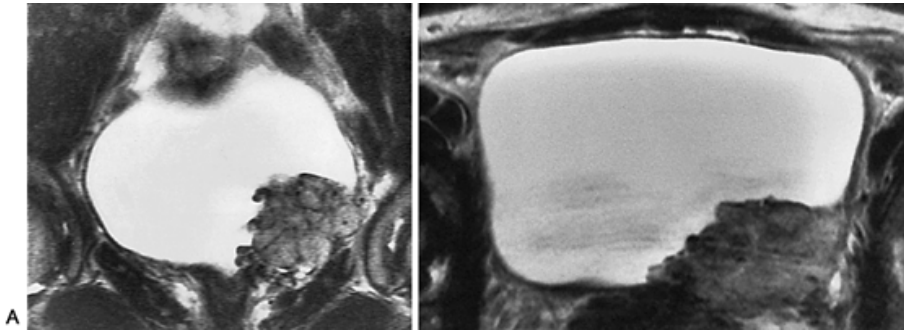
20. Transmural invasion of bladder tumor using phased-array surface coils. A: A coronal T₁-weighted magnetic resonance imaging (MRI) demonstrates a papillary mass within the base of the bladder with extension outside the bladder wall. B: Axial T₁-weighted MRI demonstrates the extent of the mass through the wall in another plane.
